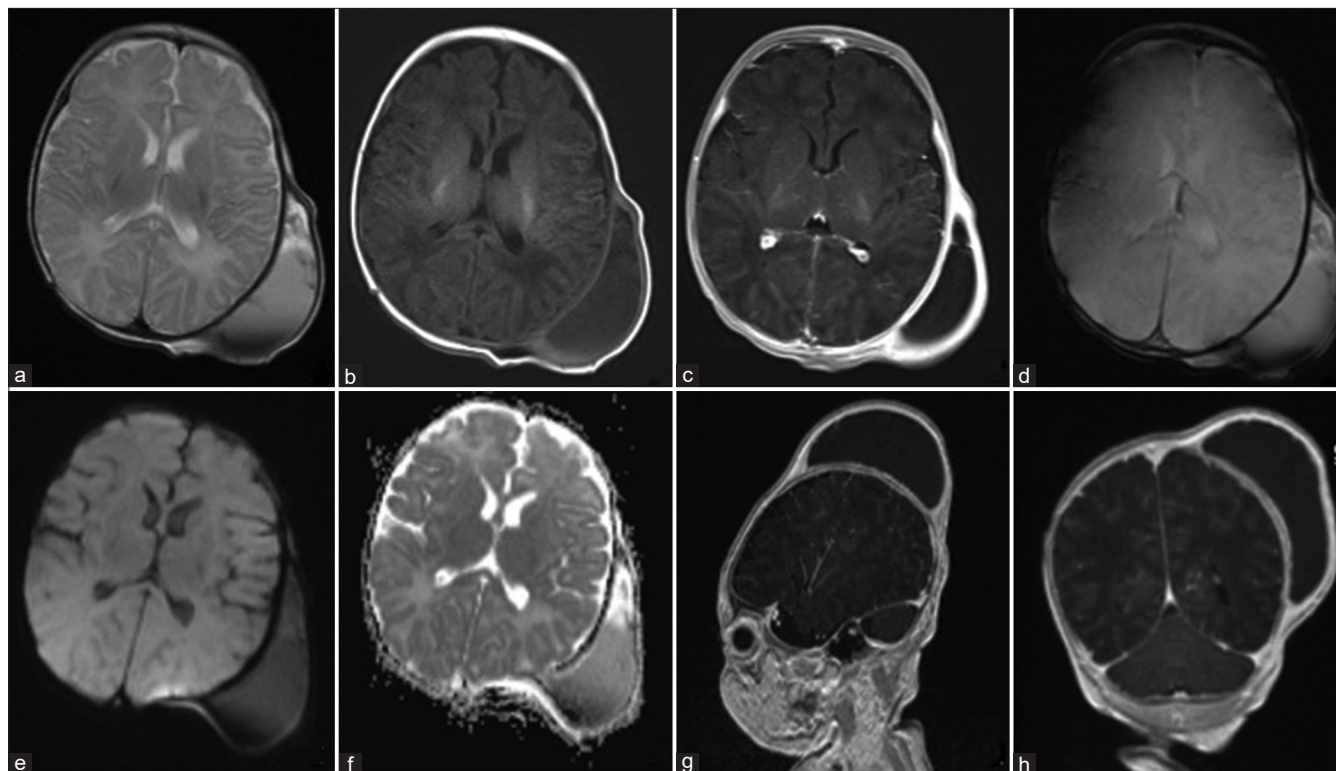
(a-h) Magnetic resonance imaging (MRI) study of the patient's brain on presentation to our institution. Select axial T2-weighted non-contrast (a), T1-weighted non-contrast (b), T1-weighted post-contrast (c), gradient echo (d), diffusion-weighted imaging (e), apparent diffusion coefficient (f), sagittal T1-weighted non-contrast (g), and coronal T1-weighted non-contrast (h) images from an MRI study of the patient's brain. Images demonstrate a large heterogeneous extracranial fluid collection overlying the left parietal skull consistent with a cephalohematoma. The collection does have some enhancement along its margins, but does not demonstrate restricted diffusion. No significant surrounding subcutaneous edema is identified. No acute intracranial findings or abnormalities noted.
